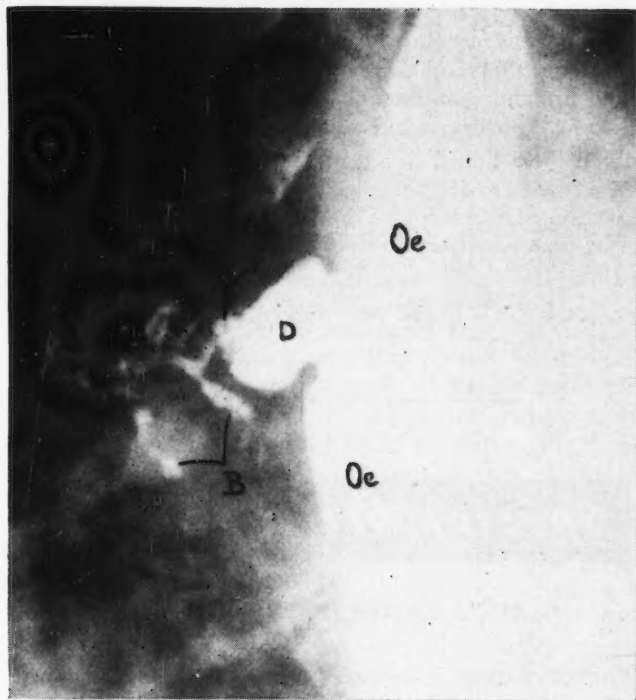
Roentgenographic examination of the œsophagus with barium showing the œsophagus (Oe), the diverticulum (D), fistula (F), and bronchus (B).
